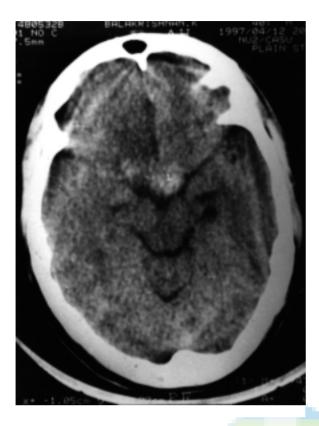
Plain CT scan showing blood within the pituitary adenoma and extension into the right parasellar region.
